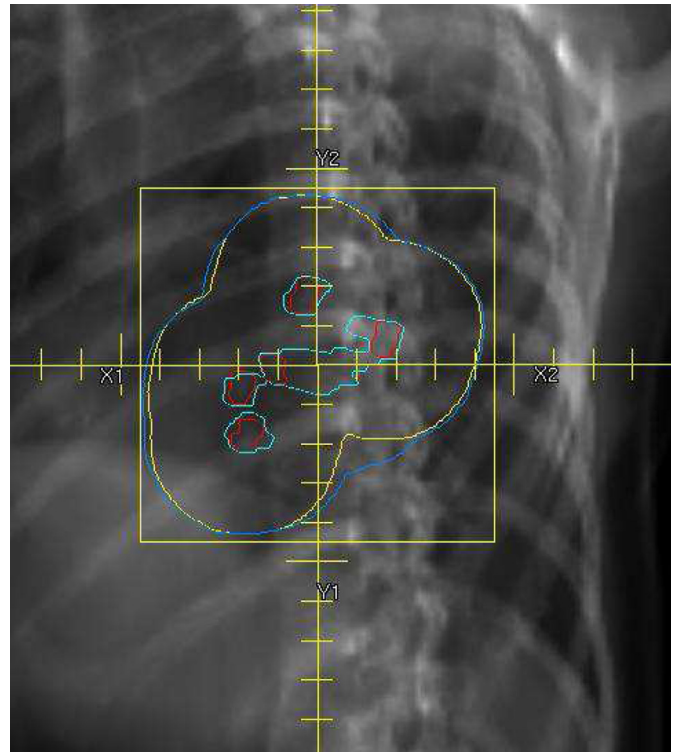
Clips outlined by radiographer (red) and consultant (sky blue). The included seroma by the consultant made little difference to the overall PTV, respectively, radiographer (yellow) and consultant (light blue).
